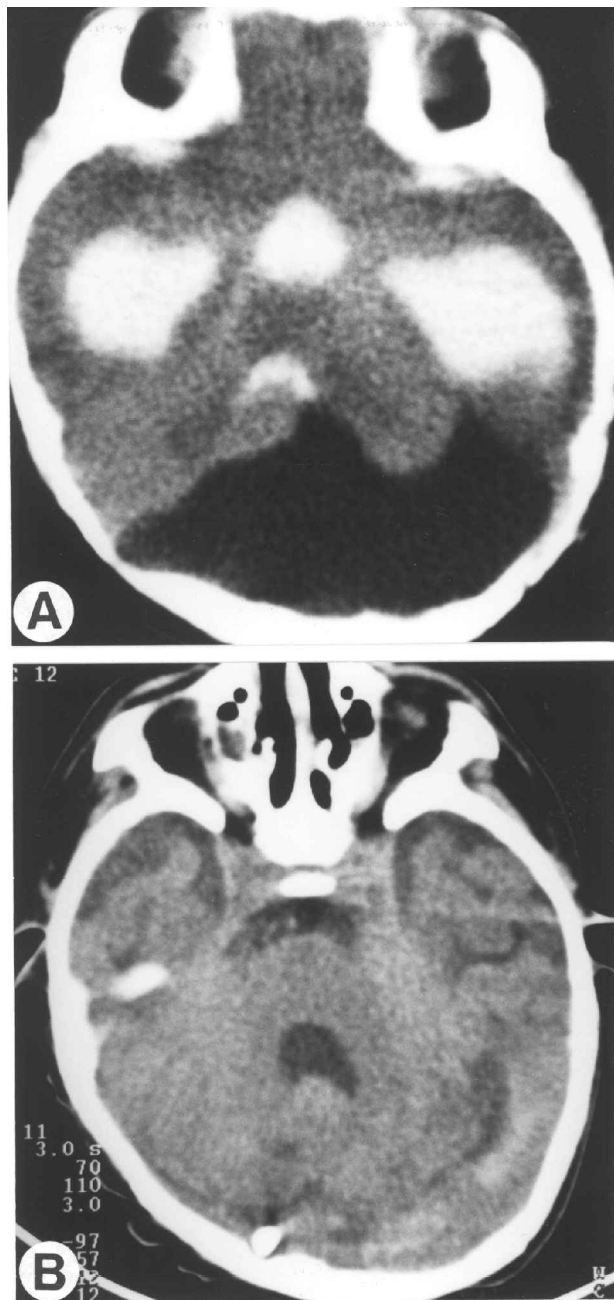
Case 9. (A) A non-communicating retrocerebellar posterior fossa arachnoid cyst is seen on axial CT scans after intraventricular injection of contrast via the bregmatic fontanel. (B) A reduction in cyst and ventricular size is seen after insertion of a Y connected ventriculo-cysto-peritoneal shunt.
